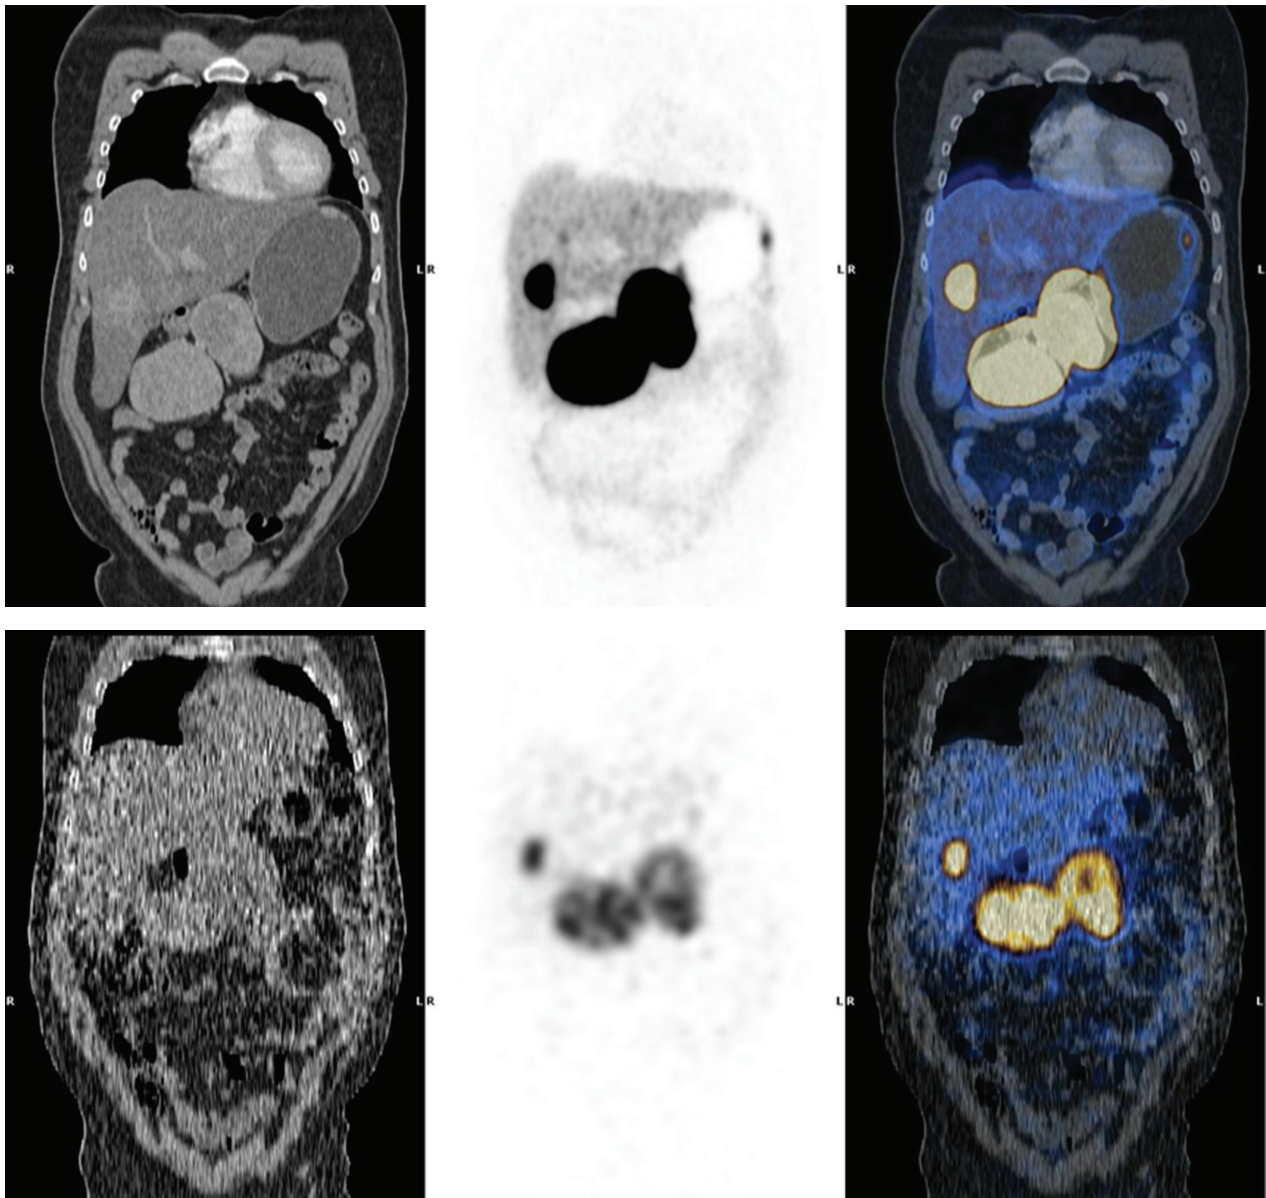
A: Coronal section of disease burden on $[^{68}\text{Ga}]\text{Ga-DOTA-NOC}$ PET/CT showing retroperitoneal, sub hepatic, and liver segment V lesion. B: Coronal section of disease burden on $[^{99\text{m}}\text{Tc}]\text{Tc-HYNIC-TATE}$ SPECT/CT showing retroperitoneal, sub hepatic, and liver segment V lesion.
